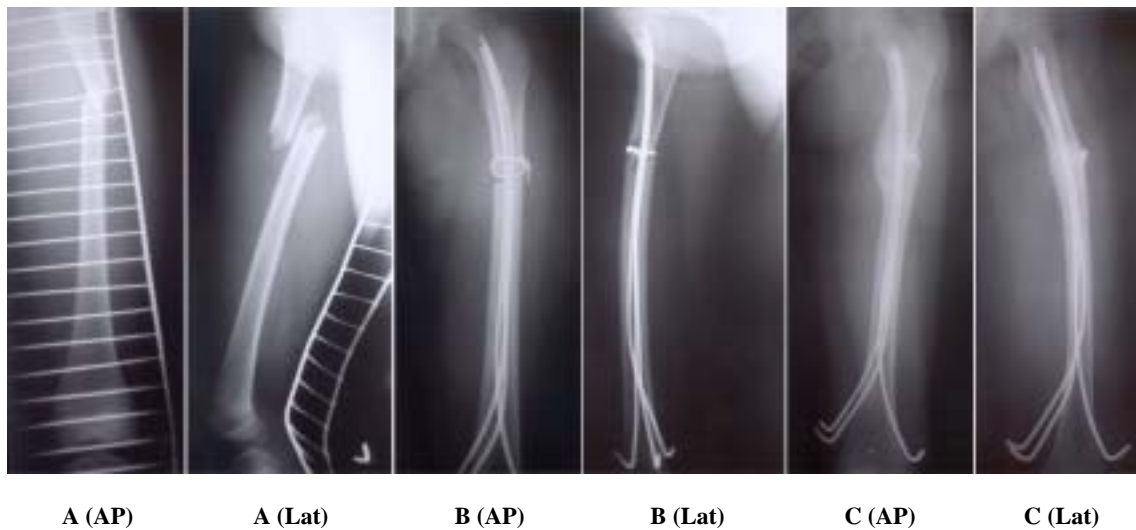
Serial radiograph of 7 year old girl treated by Nancy nail.
